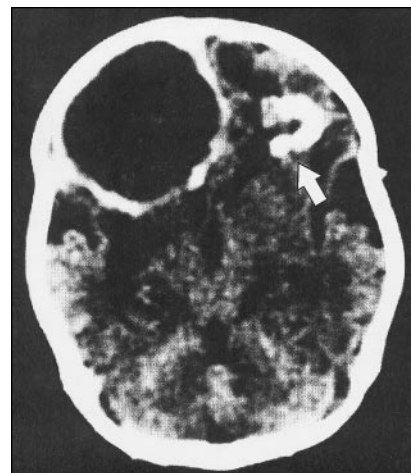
Computed tomography without contrast enhancement of a neonatal brain abscess with calcification in the abscess wall. More densely calcified smaller abscesses are visible in the opposite frontal lobe (arrow).
